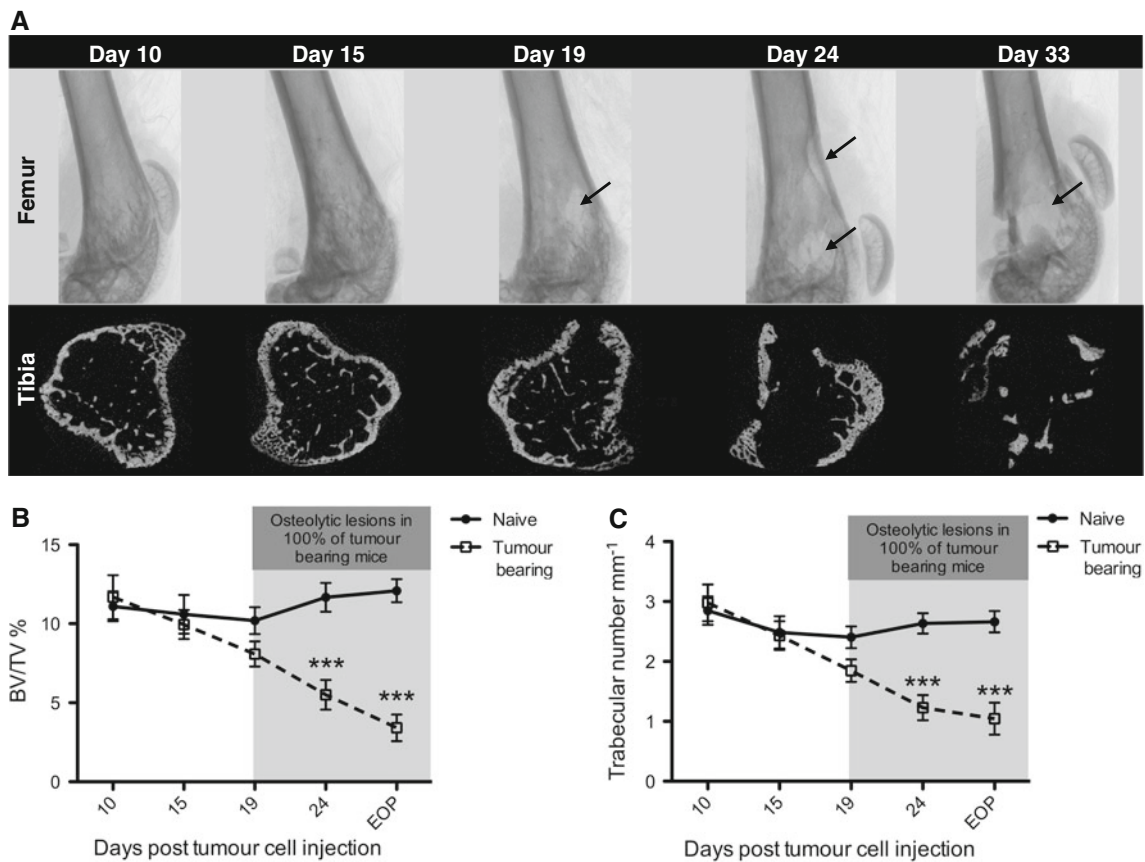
Development of osteolytic lesions. a *Top panel*: example radiographs of the distal femur for each time point taken from μ CT analysis. *Arrows* indicate osteolytic lesions. *Bottom panel*: visualisation of trabecular bone on uCT cross-sections of the proximal tibia. b μ CT analysis of trabecular bone is depicted as % BV/TV and was carried out for the proximal tibia and distal femur of tumour bearing
